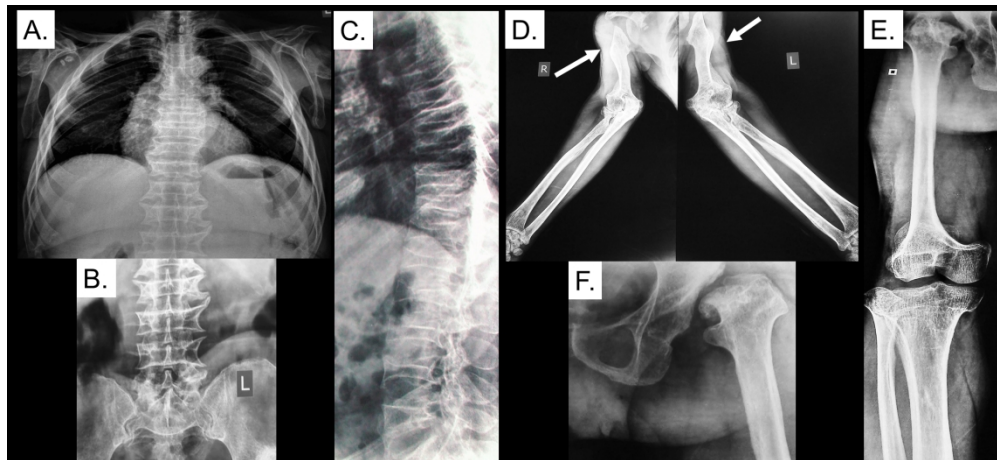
Radiographs of individual IV:4 at 50 years.
